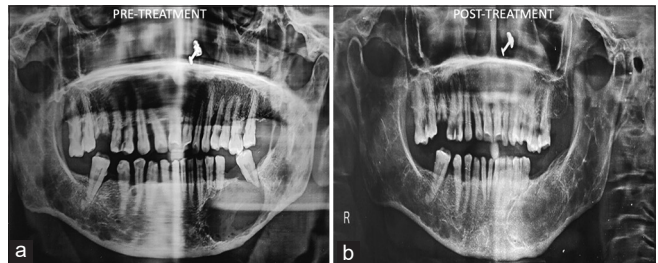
(a) Pre- and (b) Post-treatment Orthopantomographs
